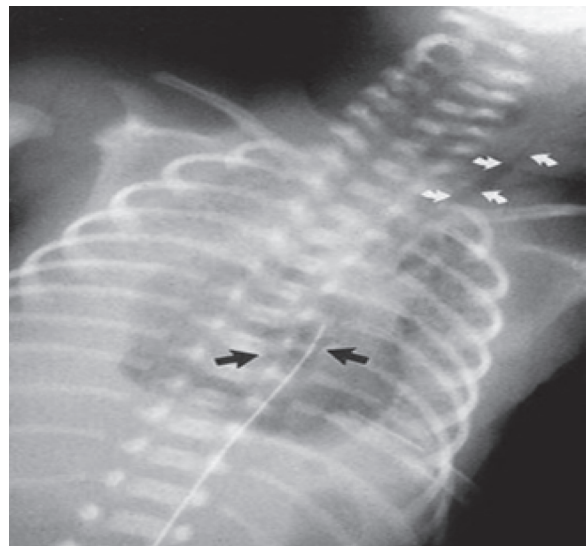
Postmortem x-ray of a baby who died from systemic air embolism. Gas can be seen (black arrows) within the heart and in the great vessels in the neck (white arrows). (From Bancalari E: Bronchopulmonary dysplasia and neonatal chronic lung disease. In Fanaroff AA, Martin RJ, ed. *Neonatal-Perinatal Medicine Diseases of the Fetus and Infant*, 9th ed. St Louis: Mosby-Elsevier, 2011.)
